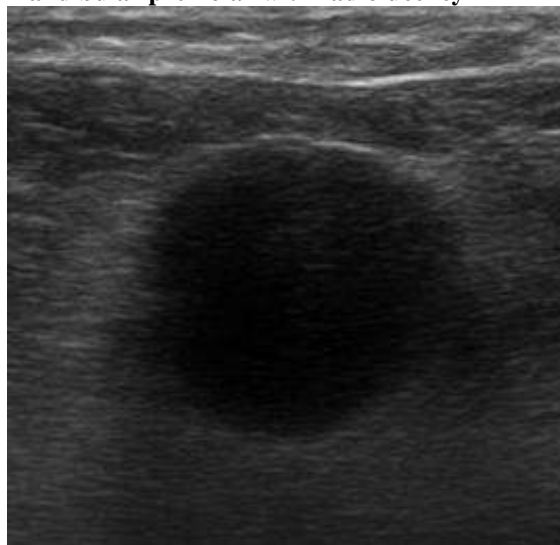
Corresponding ultrasound B-mode image of the same lesion, showing a hypoechoic region with defined margins
